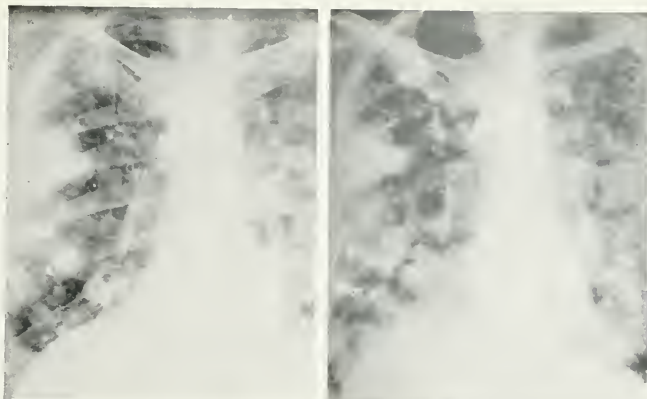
Roentgenogram of chest of patient August, 1921, showing metastatic tumors in both lungs.
